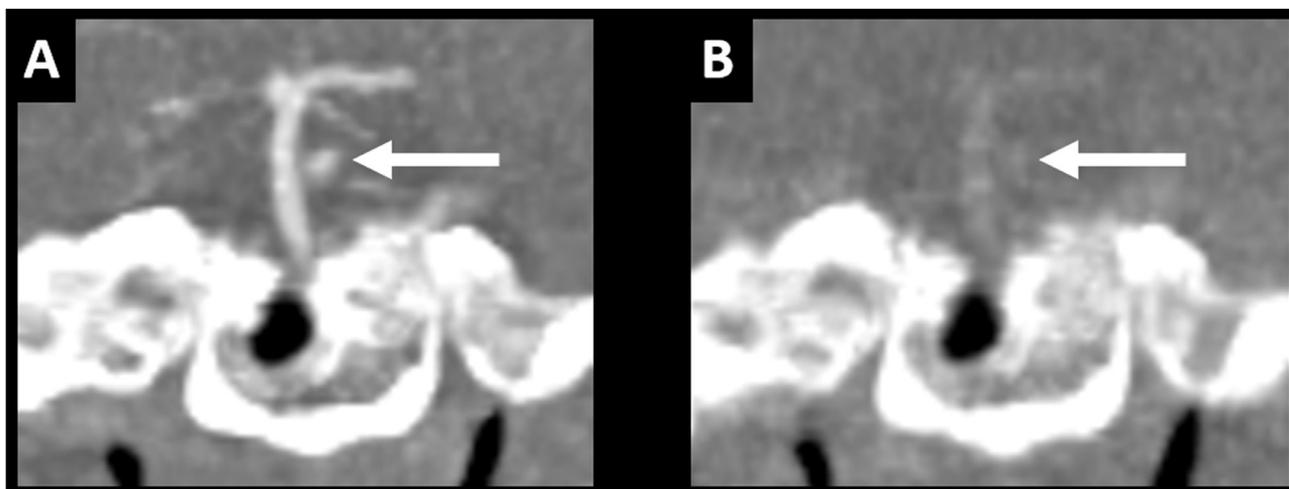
Coronal reformatted images from dynamic contrast-enhanced CT obtained at 1 week before the onset of neurological symptoms. The early phase image (A) revealed the presence of an ovoid enhanced lesion close to the basilar artery. The delayed phase image (B) indicated that there was reduced attenuation of both the basilar artery and ovoid lesion. The similar densities as observed in both the early and delayed images indicate that the ovoid lesion was an aneurysm that had not yet thrombosed.
